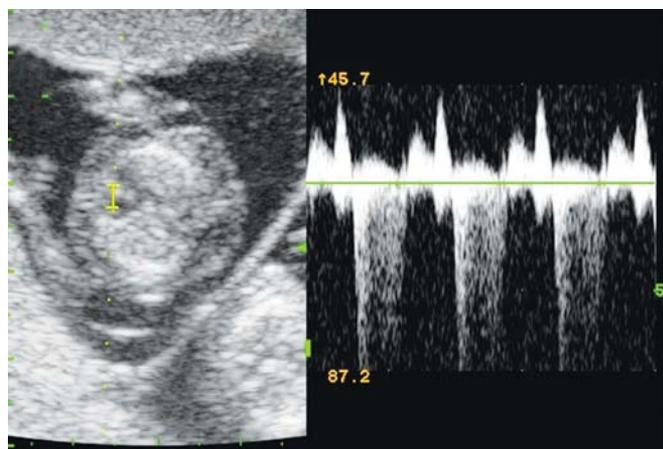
Doppler sign of tricuspid valve blood flow regurgitation
